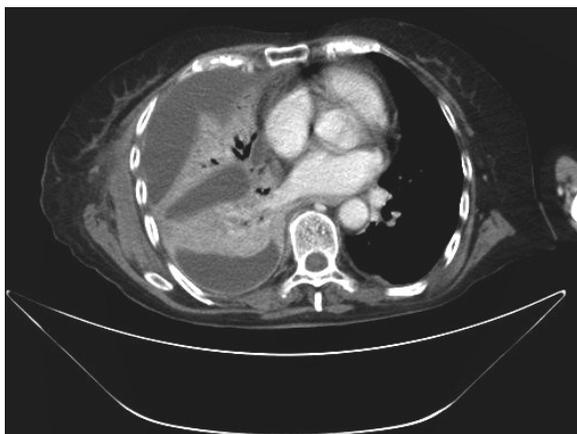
Chest CT scan showing the right pleural effusion.
